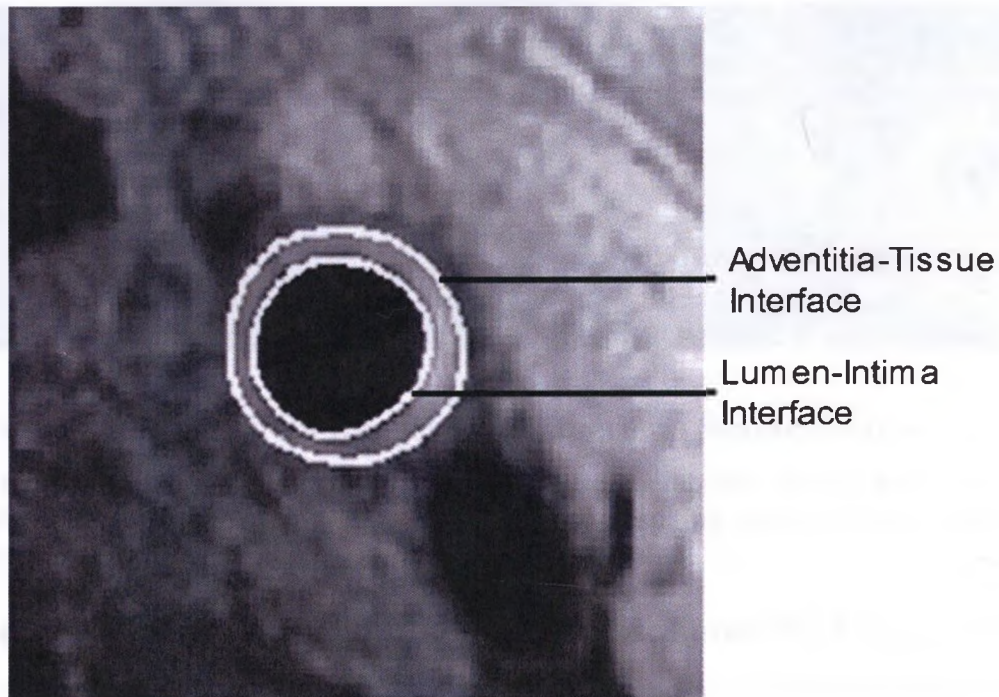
Sample Magnetic Resonance Imaging Mean Wall Thickness Image.
